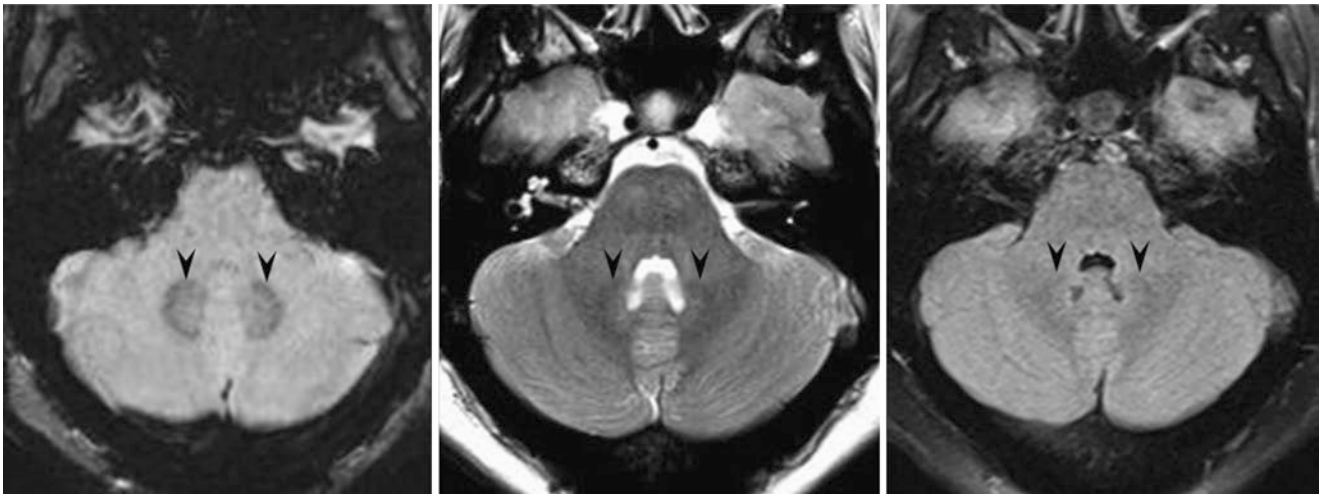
A 35 year old with a negative 3T MRI performed to evaluate for multiple sclerosis. SWI (*left*) depicts iron within the dentate nuclei (*arrowheads*). The dentate nuclei can often be visualized on T2WI (*middle*) in the middle aged and elderly as a result of the T2* effects of iron. This dark signal from iron is usually less visible on FLAIR (*right*)
